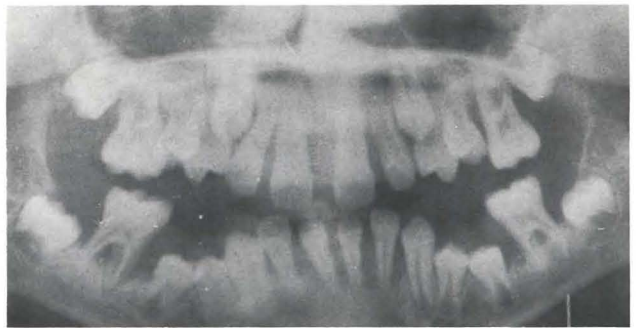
Panoramic radiograph of the ten-year-old boy, showing severe bone loss, and positions of unerupted teeth.
